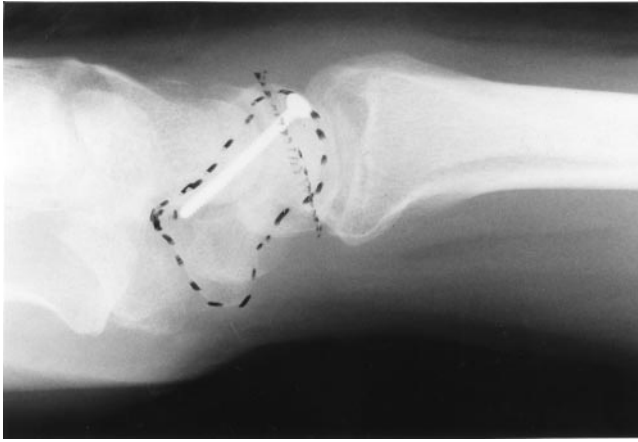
Lateral X-ray demonstrates the correct position of AO minifragment screw.
